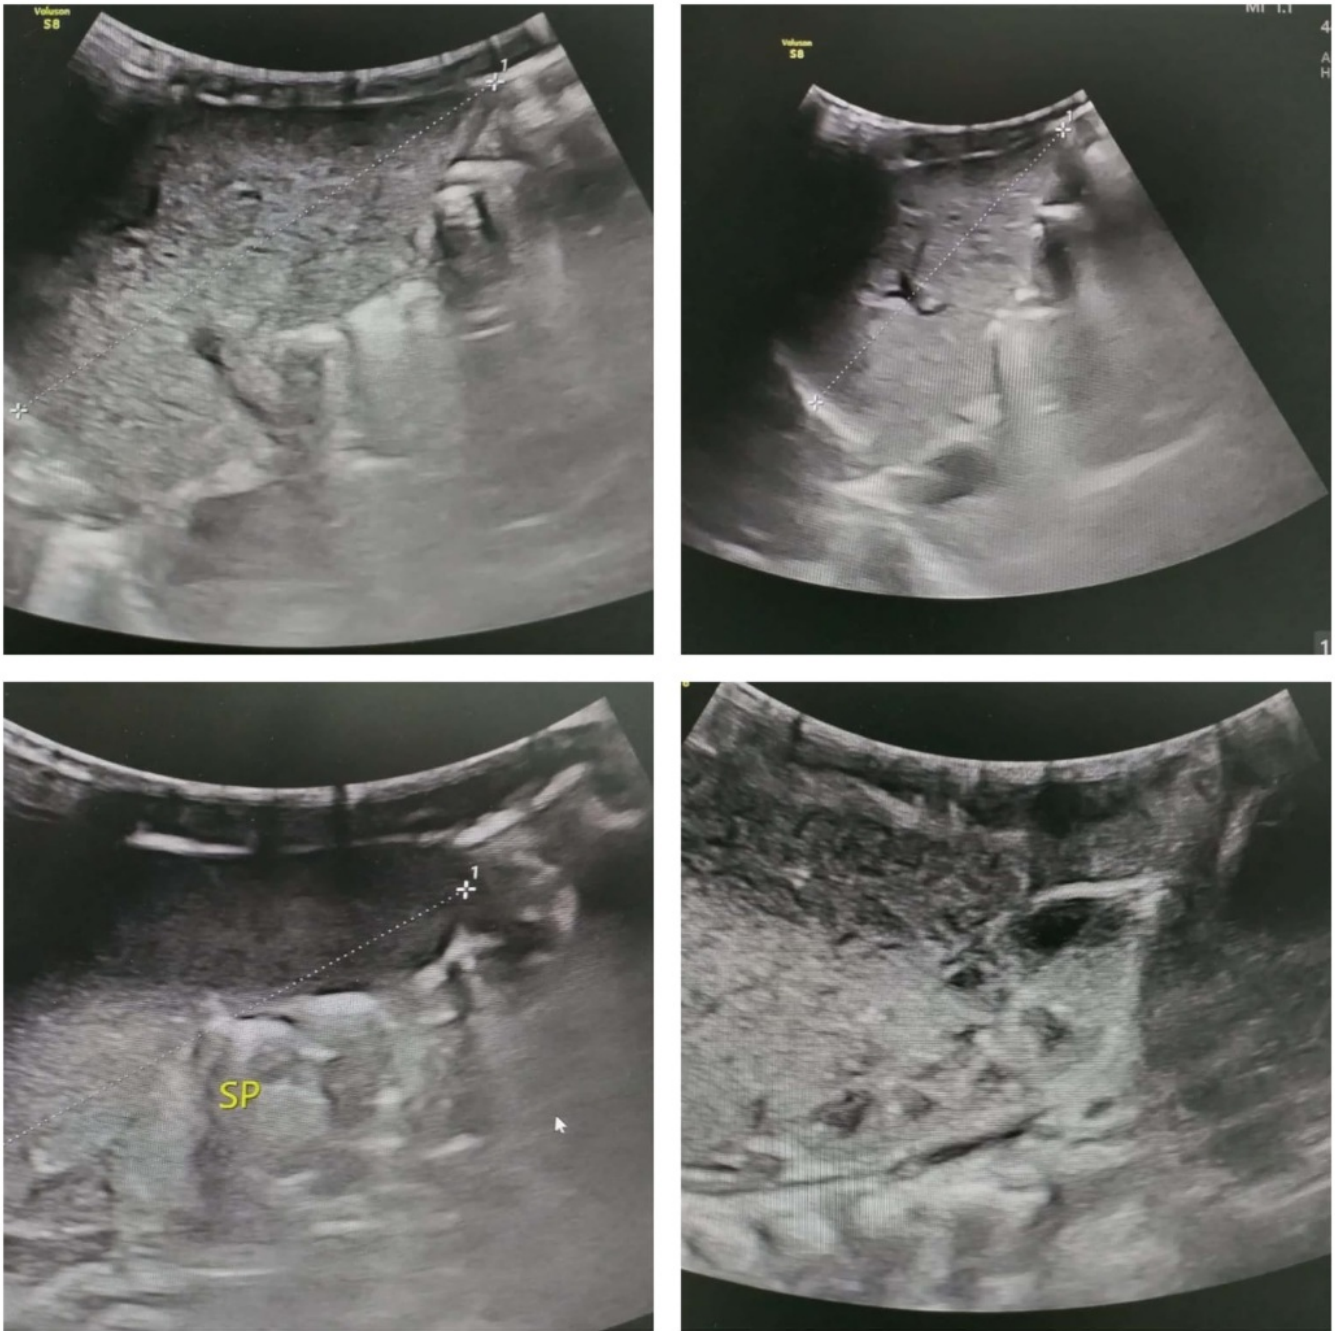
The abdominal ultrasound revealed mild hepatomegaly, with the liver measuring 8 cm in size and displaying a homogeneous echo pattern. Additionally, mild splenomegaly was noted, with the spleen measuring 6.7 cm. The absence of focal lesions or dilated intrahepatic biliary radicles suggests a uniform enlargement of the liver. These findings, along with the presence of hepatosplenomegaly, indicate a systemic condition affecting both organs, consistent with the presentation of congenital leukemia.
